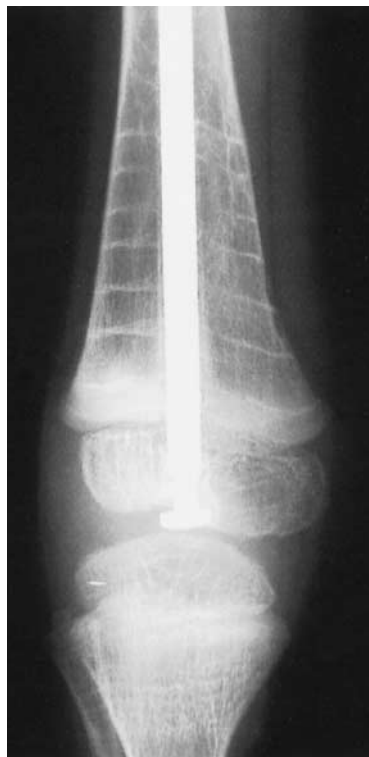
Anteroposterior Radiograph Showing Sclerotic Bands in the Metaphysis of the Distal Femur in an Eight-Year-Old Boy with Osteogenesis Imperfecta.
